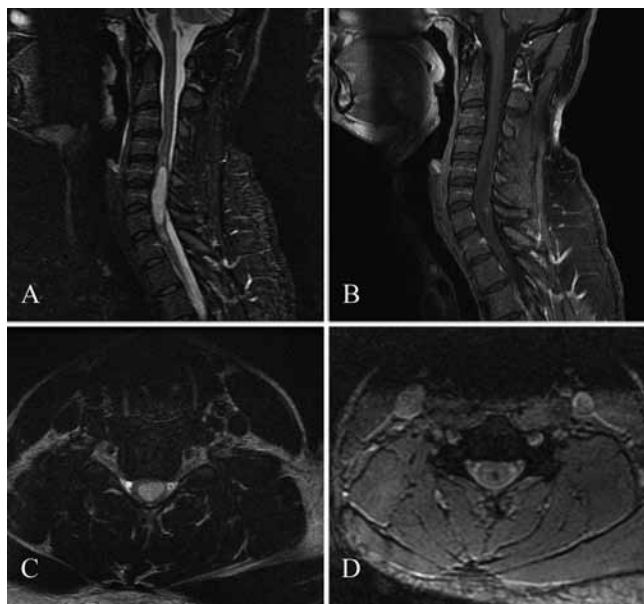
Preoperative MR imaging in Case 1. A and C: Sagittal (A) and axial (C) T2-weighted images demonstrating a hyperintense cervical intramedullary lesion. B: Sagittal T1-weighted postcontrast image demonstrating a hypointense lesion with a small inferior region of enhancement. D: Axial T2*-weighted gradient echo image demonstrating central cord hypointensity consistent with blood products.
